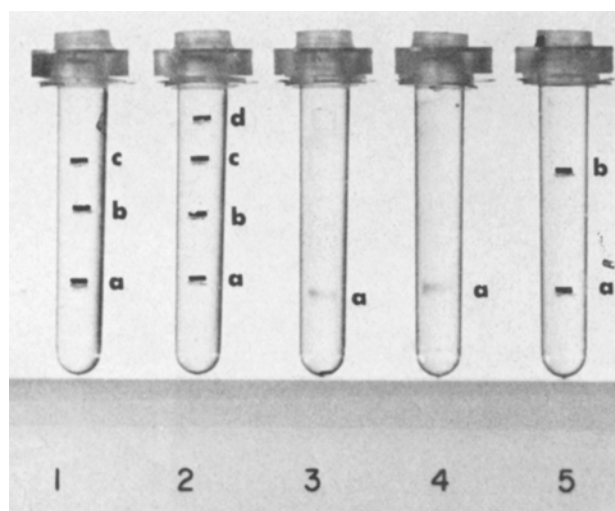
Polyacrylamide gel electrophoresis. Electrophoretic behavior on polyacrylamide gel containing 0.015M ϵ -aminocaproic acid. 1. Thrombin treated purified human fibrinogen. 2. Thrombin treated 2-min ultrasonicated human fibrinogen. 3. Purified human fibrinogen. 4. Two min ultrasonicated human fibrinogen. 5. 60 min ultrasonicated human fibrinogen.
